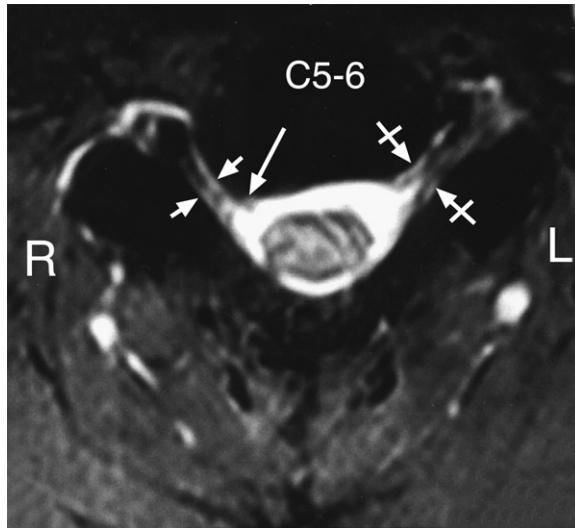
Cervical spine MRI axial C5-6 image. Note the posterior disc bulge (white arrow) which is more prominent to the right (R) of the midline causing (i) mild indentation of the dural tube, and (ii) mild narrowing of the right neural exit foramen (two small white tailed arrows) which is narrower than the foramen on the left (L) side (two white tailed arrows).
